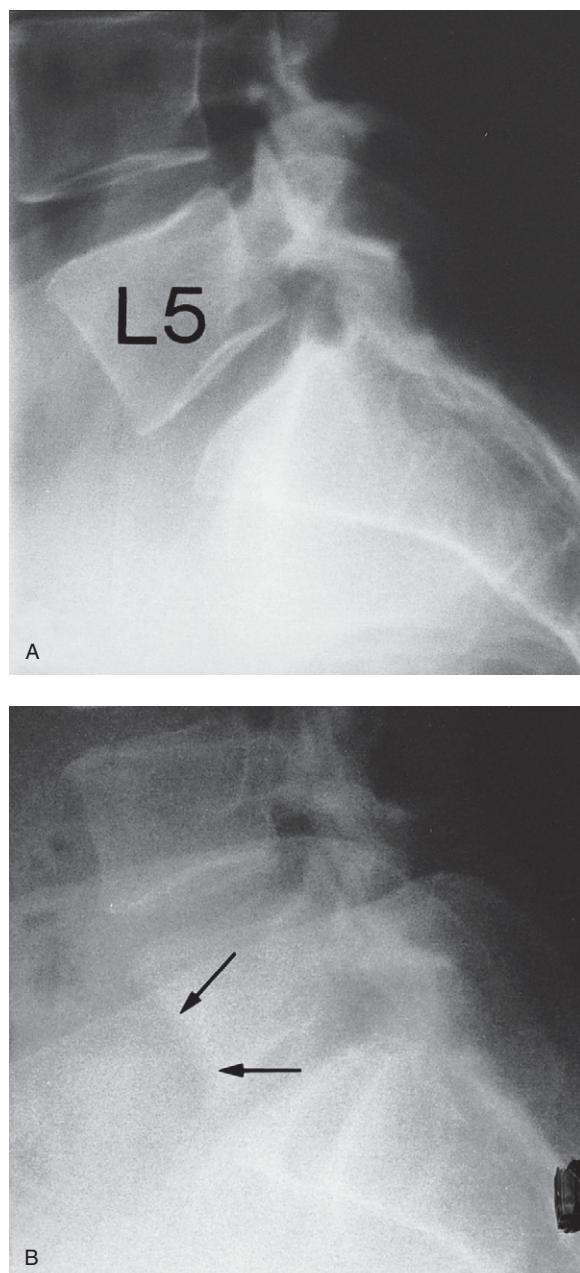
(A) Lateral plain X-ray image of the L4–S2 level. Note the 'minimal narrowing of the L5–S1 intervertebral disc'. (B) Lumbosacral spine lateral plain X-ray image of the region taken 12 months after the X-ray shown in (A). Note the minor concave appearance of the anterior aspect of the L5 vertebral body (arrows). *(Continued)*
